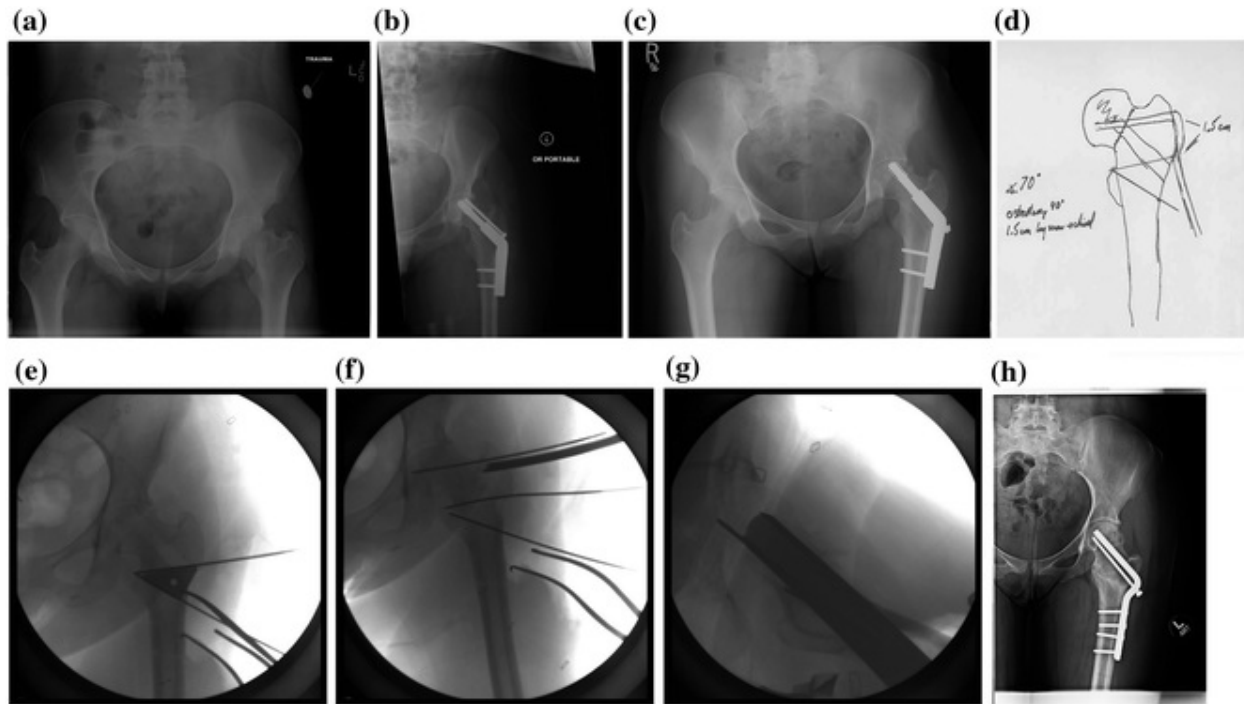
Corrective osteotomy of femoral neck nonunion: a injury radiograph note vertical angle; b initial fixation; c nonunion, note varus, and shortening; d surgical template—fracture angle is 70° , a 40° correction will result in an angle of 30° , and osteotomy is planned 1.5 cm distal to projected blade insertion site; e intraoperative templating; f placement of chisel anteroposterior view; g placement of chisel lateral view; h healed nonunion and osteotomy
